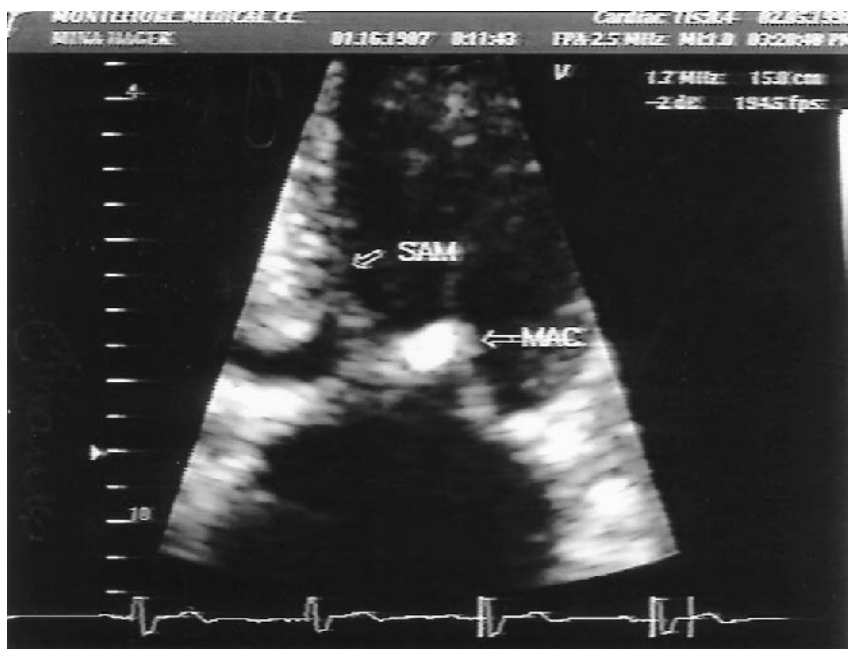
Systolic frame of a two-dimensional echocardiogram from an apical view in a 91-year-old female with hypertrophic cardiomyopathy of the elderly, showing extensive mitral annulus calcification and prominent systolic anterior motion of the mitral valve with near obliteration of the LVOT. SAM = Systolic anterior motion of the mitral valve leaflets. MAC = mitral annulus calcification.
